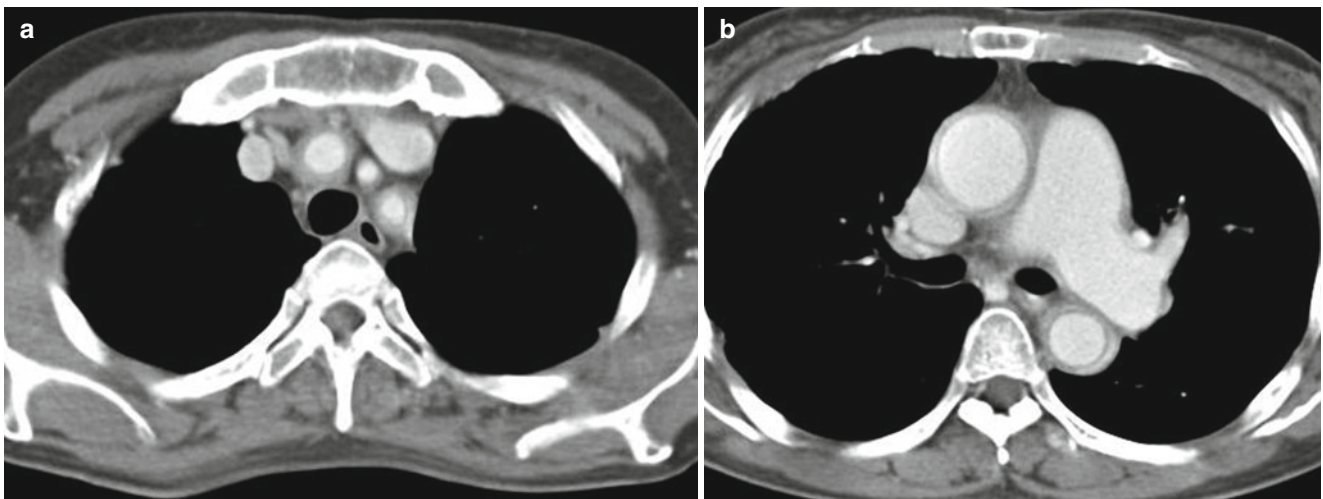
A 49-year-old woman with active stage of Takayasu arteritis. (a) Transaxial contrast-enhanced CT image shows concentric wall thickening at the right brachiocephalic and the left subclavian arteries.
